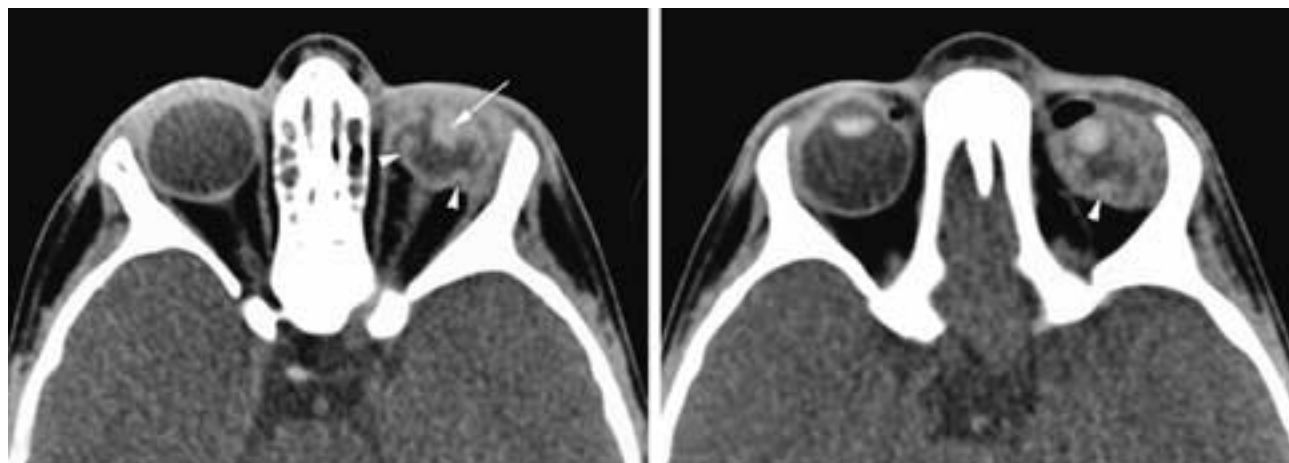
Perforation and collapse of the globe. Axial CT scans show infolding (arrowheads) of the posterior aspect of the globe, and the lens (arrow) is partially displaced.
